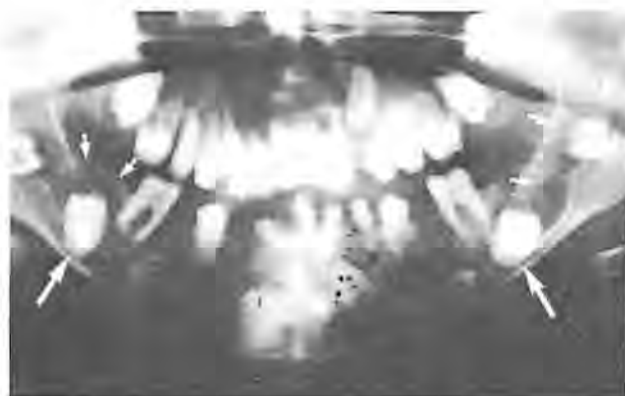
Case 1. Panoramic radiograph showing unerupted teeth with pericoronal radiolucencies (small arrows). No evidence of enamel is present and the unerupted molar teeth show gross root disfigurement (large arrows).
